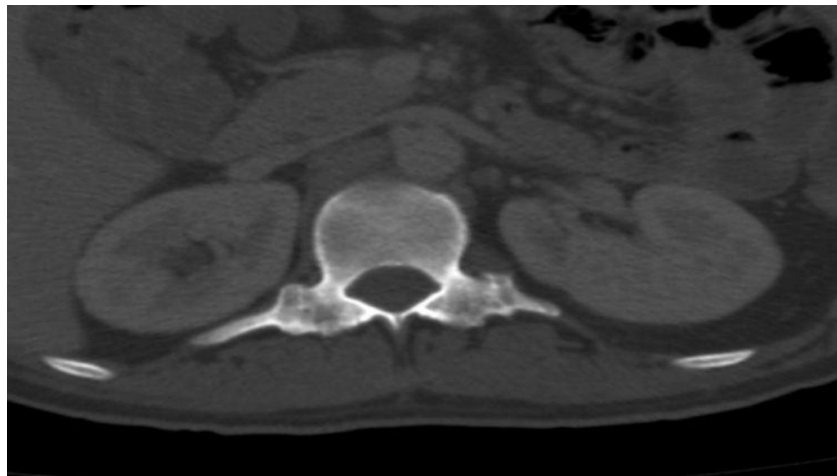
Axial CT section in bone window, where shows ankylosis of both costovertebral synovial joints in a patient with chronic back pain. Note the continuity of the costal articular facets with the corresponding costal tufts.
